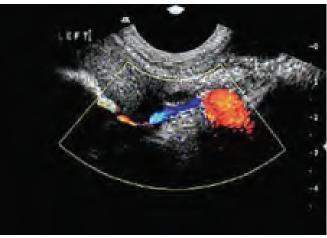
Color Doppler imaging of the fallopian tube during Hy-Co-Sy
